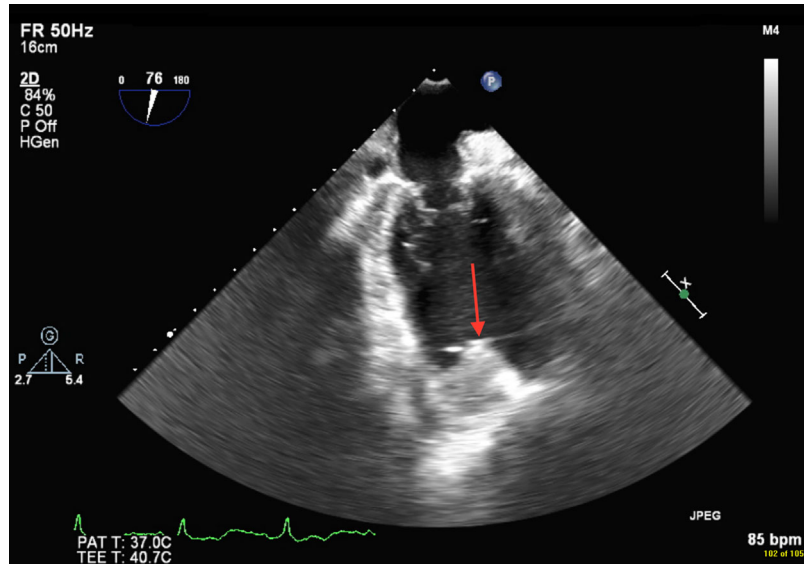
Transesophageal echocardiogram with arrow pointing to large thrombus obstructing the inflow cannula
